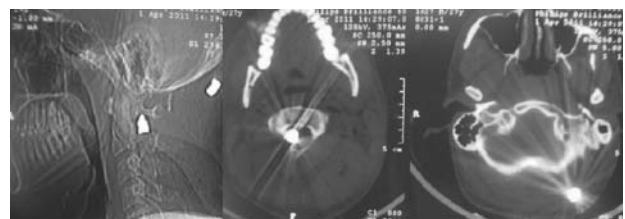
Sagittal and axial CT images showing bullets in the spinal bony canal at C2 level and in the subcutaneous tissues of occipital region
